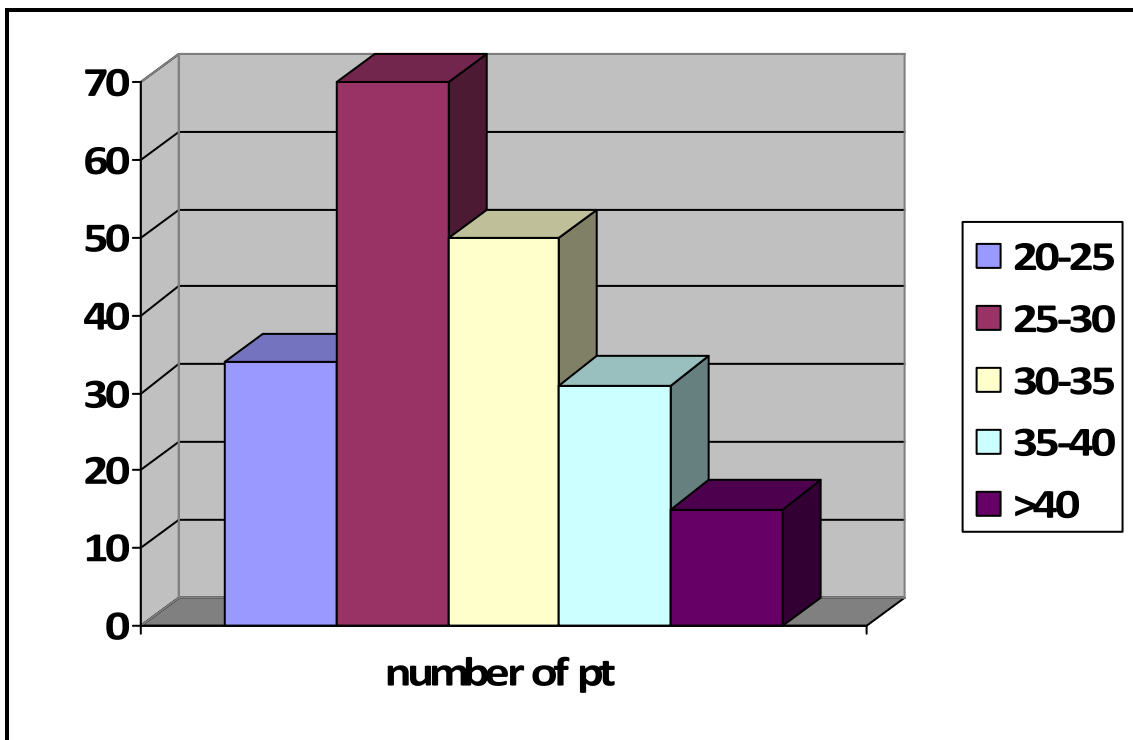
shows Distribution of the study sample according to age group among 200 pregnant women presented for obstetrical ultrasound investigation.
